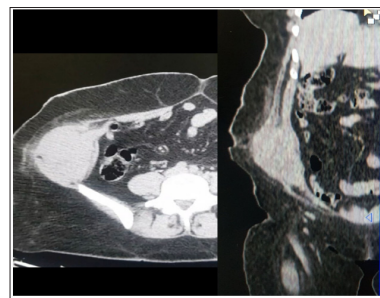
Computed tomography showing the large Lateral Abdominal wall sarcoma
